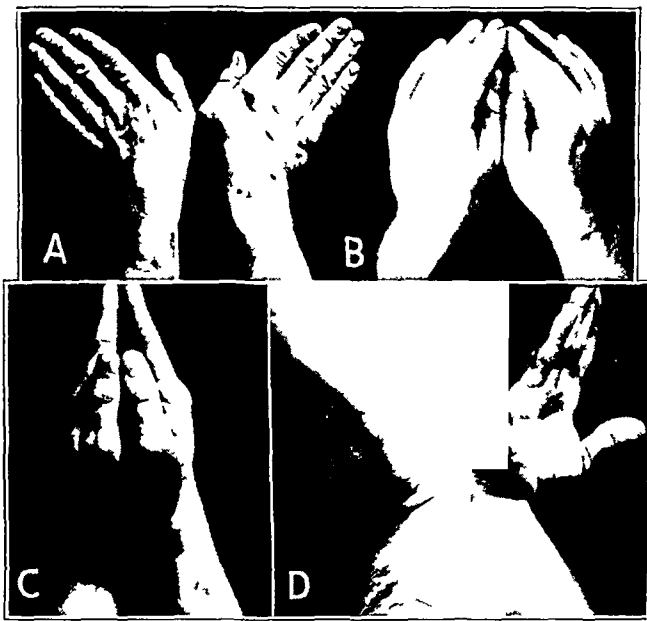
Positions of hands for roentgenograms of navicular bone. *A*, ulnar deviation, *B*, midpronation, oblique view, *C*, lateral, *D*, extreme pronation, oblique view.
